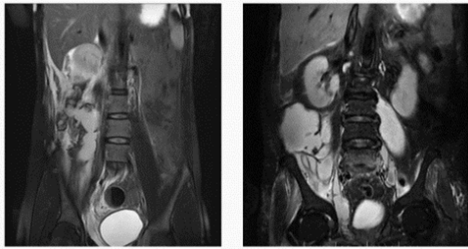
A) 19 year old haemophilic male patient presented with lower abdominal pain with fever, Coronal STIR MR image reveals, large retroperitoneal hematoma involving the right psoas muscle.
